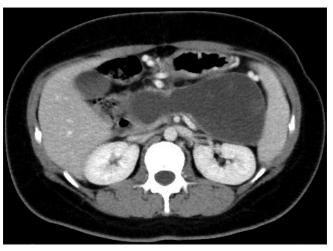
Contrast-enhanced computed tomography showing large walled-off necrosis on the dorsal side of the stomach
